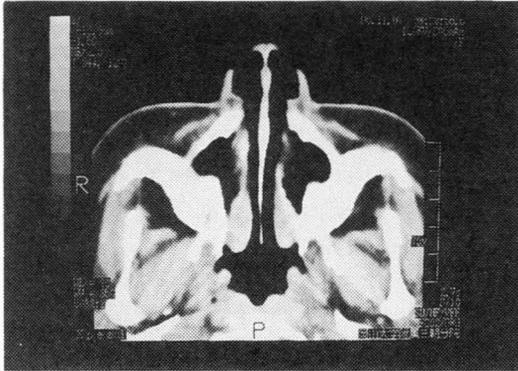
CT scans of the sinus level. Marked thickenings of nasal mucosa were observed.
